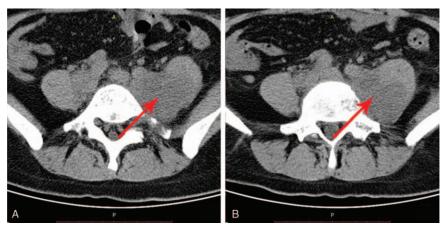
Lumbar computerized tomography shows mass in left psoas. The arrow of image A and image B showed low density in the left of 5th lumbar vertebral and vertebral pedicle with local destruction of the adjacent cortex and swelling of the left psoas with ill-defined low-density mass. (CT attenuation value 16 HU, maximum cross-section: 5.4 cm × 4.0 cm). The differential diagnosis of the CT scan findings was the 5th lumbar vertebral infection or tuberculosis (TB) with left psoas abscess.
